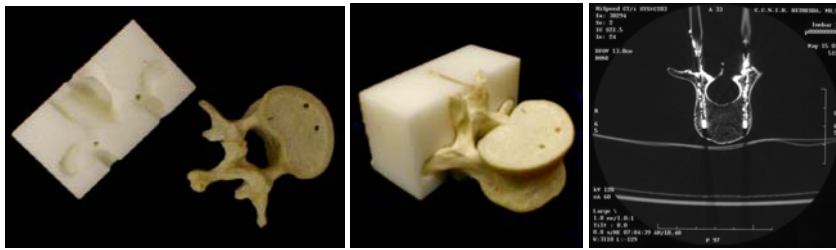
The prototype template and the dry spine test with a validating CT exam. (The pinholes in the top of the vertebrae are incidental, and leftover from the string connecting multiple vertebrae for its former use as an anatomy teaching tool.).
